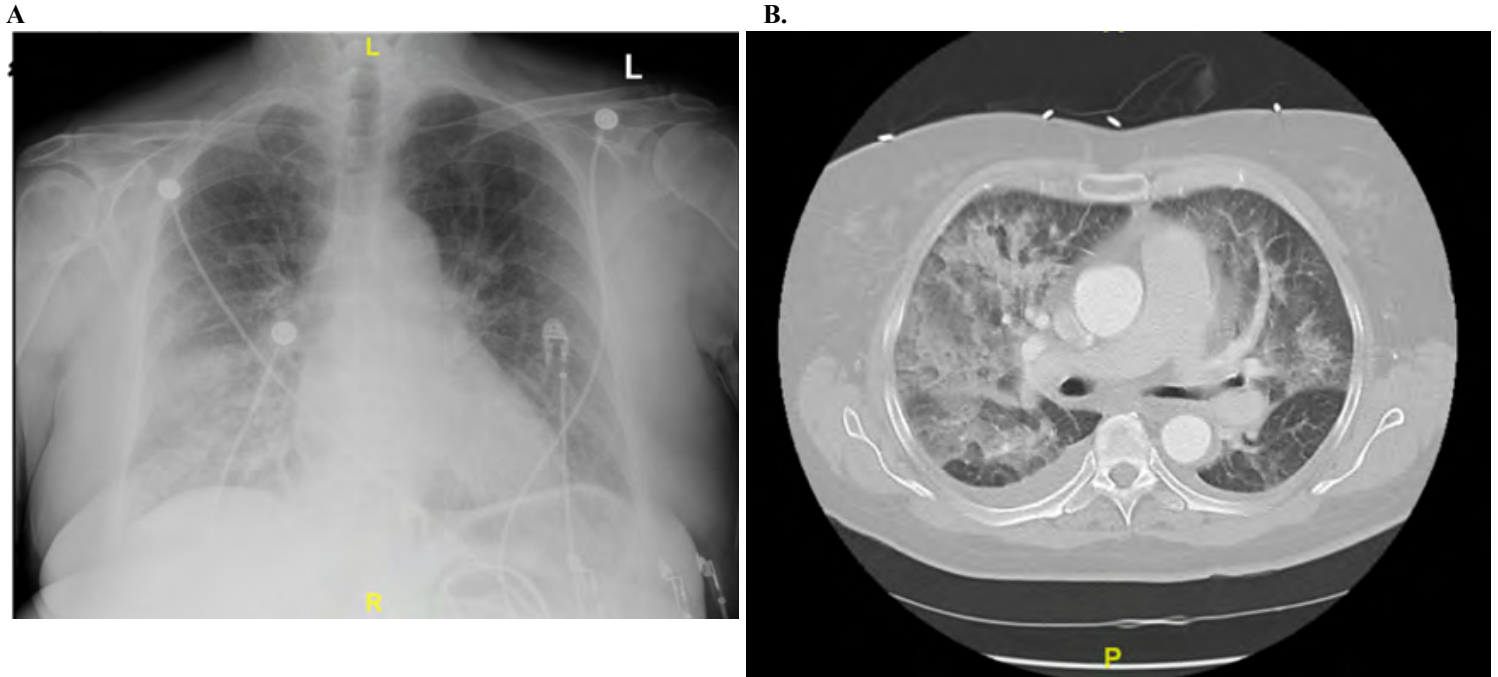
Chest Radiograph and Chest Computed Tomography on admission
